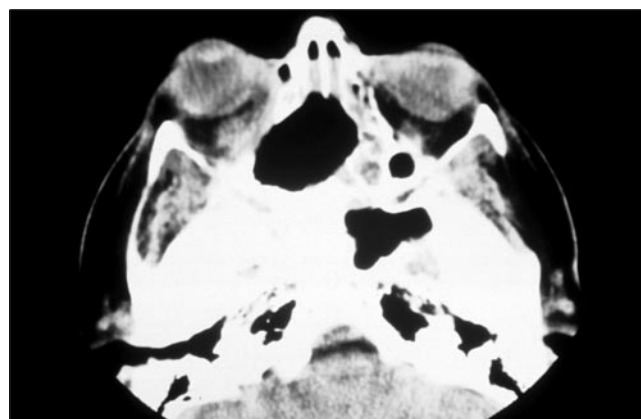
Case 3. Axial (left) and coronal (right) computed tomographic scan discloses opacification of the right maxillary and ethmoid sinuses with bony destruction of the right medial orbital floor.
